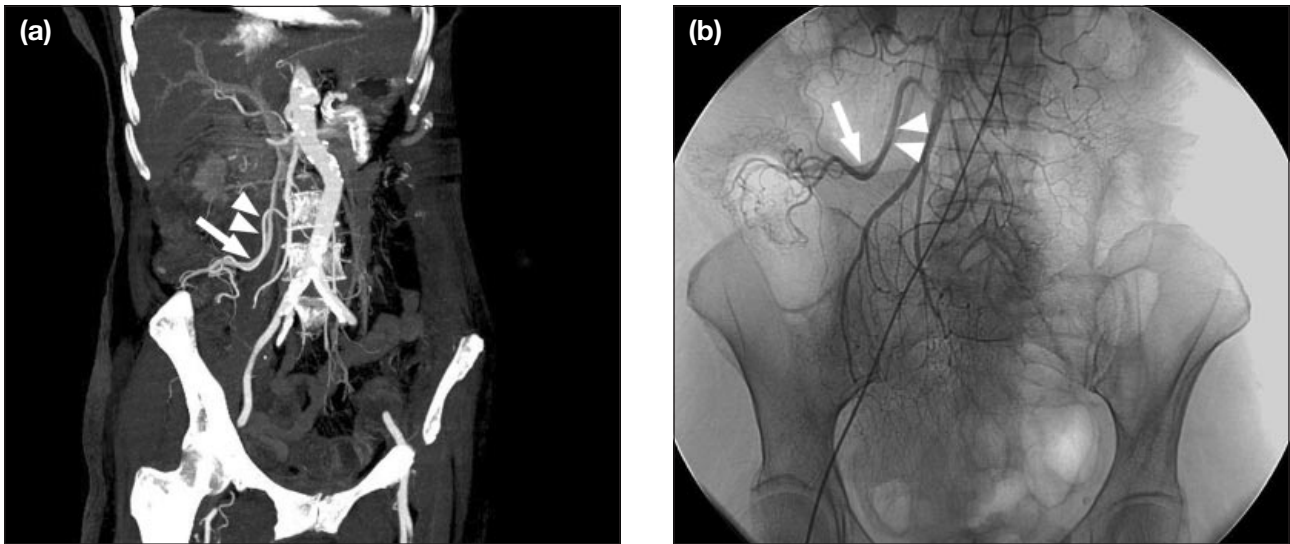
A patient presenting with fresh per rectal bleeding. (a) Multi-detector computed tomography scan (coronal reformed image with maximum intensity projection) showing a dilated artery (white arrowheads) and vein (white arrow) in the caecum; and (b) corresponding superior mesenteric angiogram showing an abnormal dilated artery (white arrowheads) with an early draining vein (white arrow) in the caecum, compatible with angiodysplasia.
